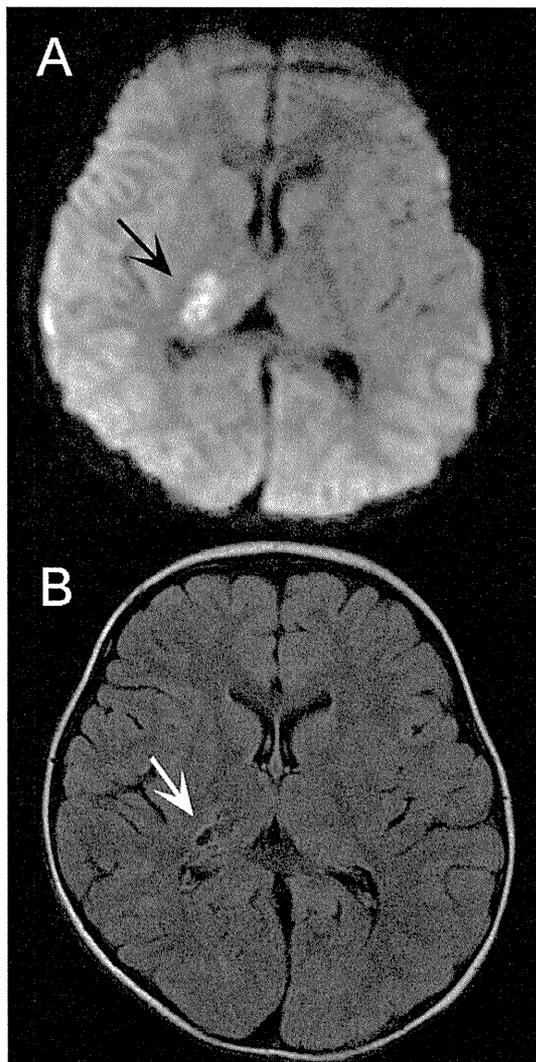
Brain magnetic resonance imaging. (A) An axial diffusion-weighted image on day 1 demonstrating restricted diffusion in the right lateral thalamus and posterior limb of internal capsule consistent with acute arterial infarct (black arrow). (B) An axial fluid-attenuated-inversion-recovery image on day 37 showing cystic changes with gliosis in the right lateral thalamus (white arrow), confirming posterior circulation infarct.
